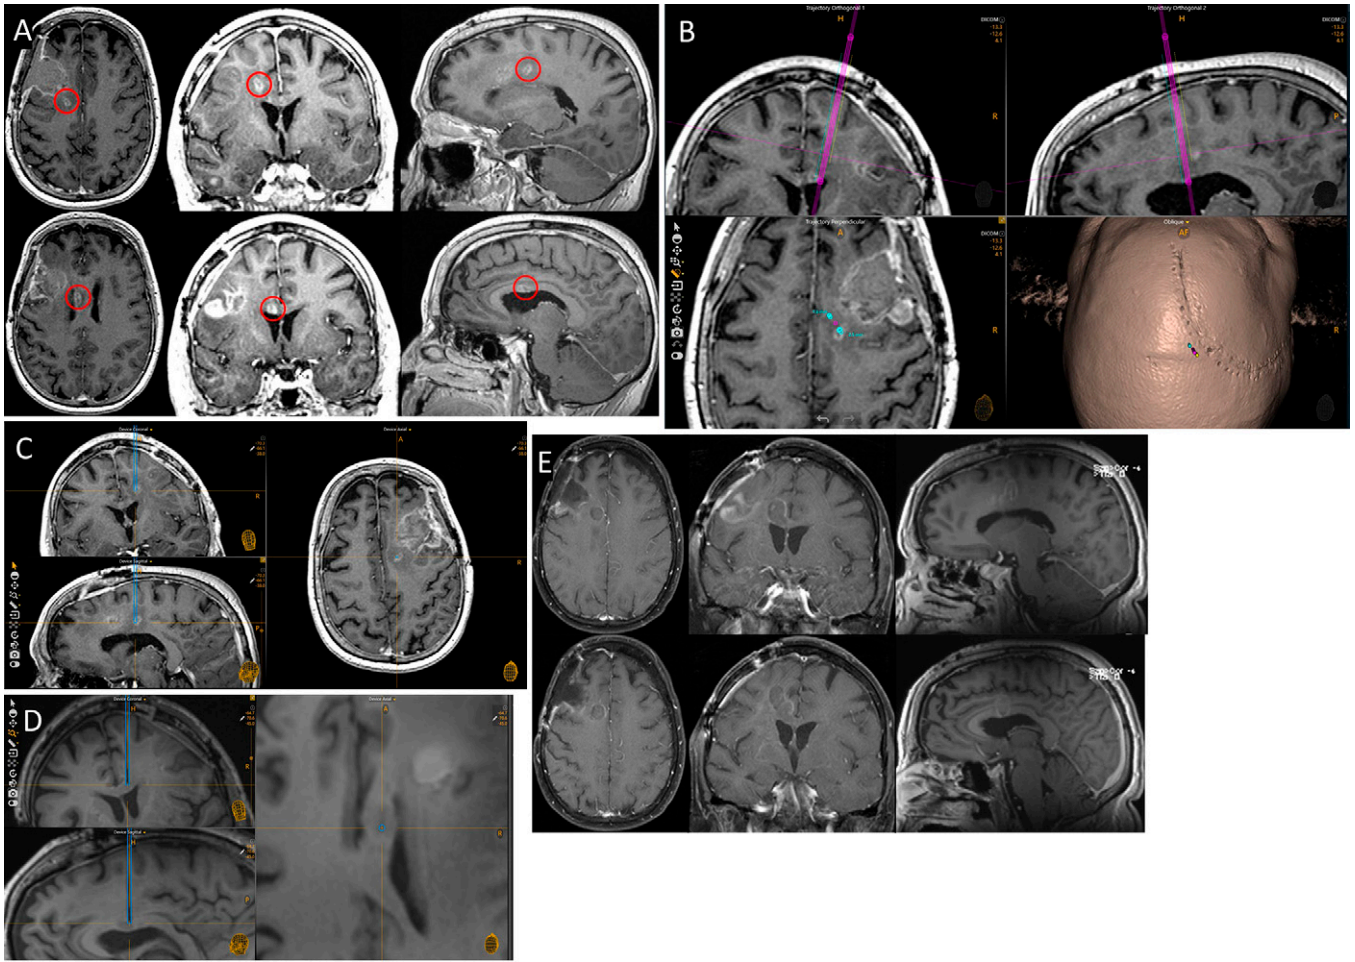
A: Axial (*left*), coronal (*middle*), and sagittal (*right*) MRI of the brain showing two new nodular lesions, located at the right cingulate gyrus (*upper*) and the corpus callosum (*lower*). The *red circle* highlights the nodular lesions. B: Trajectory planning showing access to two lesions through the ClearPoint Array frame. Coronal (*upper left*), sagittal (*upper right*), axial (*lower left*), and surface rendering (*lower right*) of the planning MRI. The *pink line* indicates the midpoint between the two planned trajectories. The *light blue lines* indicate the actual, parallel trajectories to the cingulate and the corpus callosum lesions. C: The cingulate gyrus lesion was biopsied and treated with SLA with a <1.4-mm radial error. The entire contrast enhancement was ablated. Coronal (*upper left*), sagittal (*lower left*), axial (*right*) views of the planning MRI. The *blue outline* defines the trajectory to the cingulate lesion. D: The corpus callosum lesion was biopsied and treated with SLA with a <0.8-mm radial error. The entire contrast enhancement was ablated. Coronal (*upper left*), sagittal (*lower left*), axial (*right*) views of the intraoperative MRI studies obtained after laser probe insertion. The *blue outline* defines the trajectory to the corpus callosum lesion. E: MRI of the brain performed 3 months after SLA showing local control of the cingulate gyrus lesion (*upper*) and corpus callosum lesion (*lower*).
